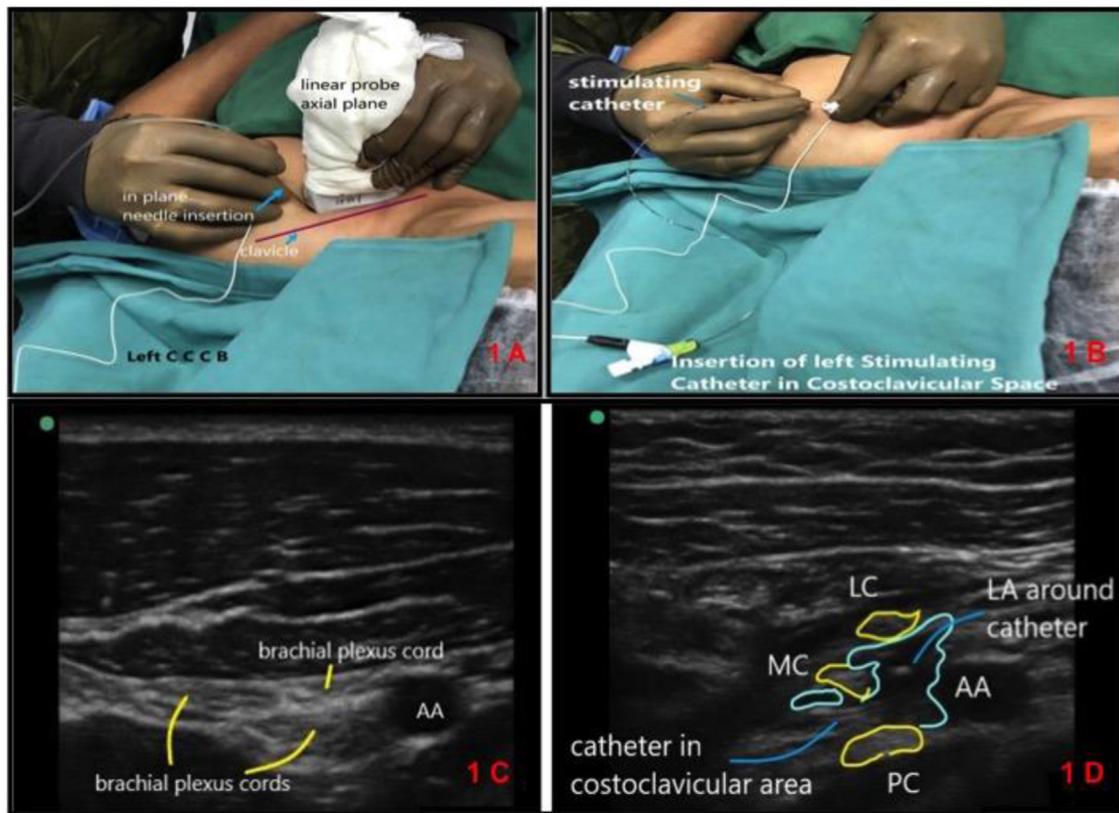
A, left Costoclavicular block: In Plane approach with a linear transducer; Needle insertion from lateral to medial. B, insertion of stimulating catheter. C, ultrasound image depicting the brachial plexus cords. D, stimulating catheter positioned in the costoclavicular space; Injection of LA displaces the cords; A hyperechoic dot is seen of the catheter.
